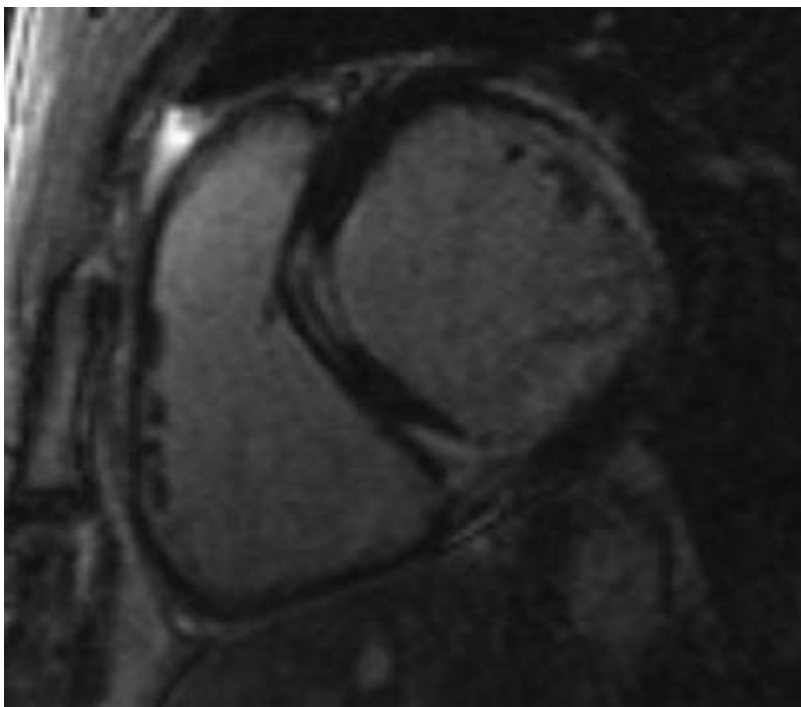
A 38-year-old man with no past medical history presented to hospital with syncope and was found to have runs of nonsustained ventricular tachycardia. His regional and global LV function was normal on echocardiography. On CMR, multiple regions of LGE are seen involving the septum (epicardial and midlateral wall). Focal expansion of the inferoseptal wall thickness is seen in this segment with LGE, consistent with myocardial infiltration. These patterns are characteristic of cardiac sarcoidosis.
